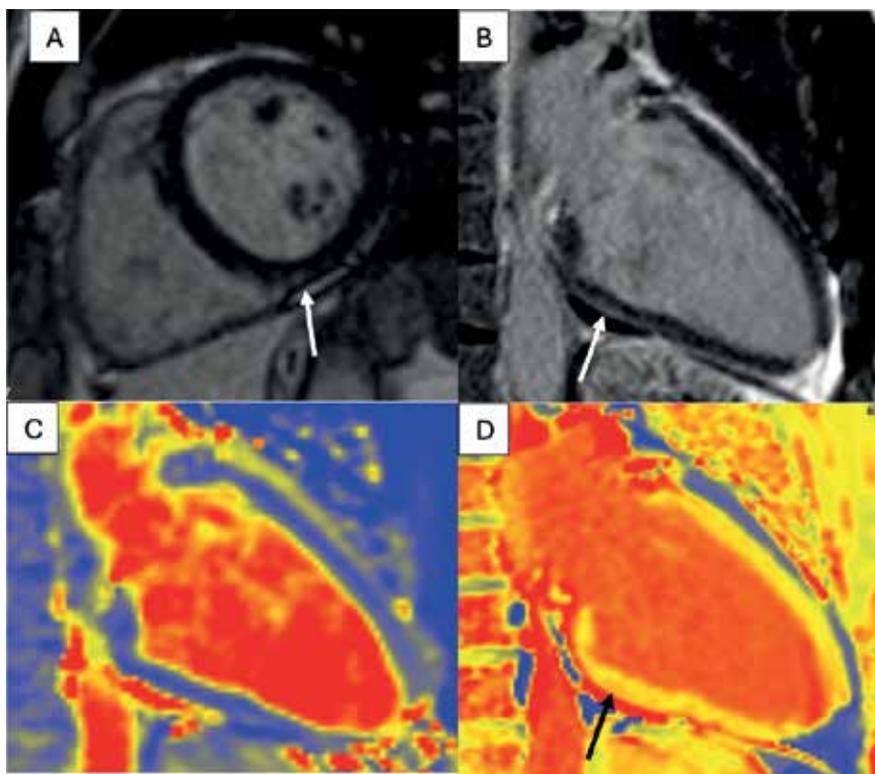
Cardiac magnetic resonance images at 11-month follow-up: Myocardial fibrosis at the right ventricular insertion point in the short-axis LGE sequence, white arrow; (B) subepicardial fibrosis in the basal inferior left ventricle segment in the two-chamber LGE sequence, white arrow; (C) myocardium without edema in the two-chamber T2 mapping sequence; (D) myocardial fibrosis in the basal segment of the inferior wall in the two-chamber native T1 mapping sequence, black arrow. The examination included cine sequences to assess myocardial function, followed by T1 and T2 mapping sequences. LGE, late gadolinium enhancement sequences were acquired 10 minutes after contrast agent injection (gadobutrol) to evaluate tissue characterization
